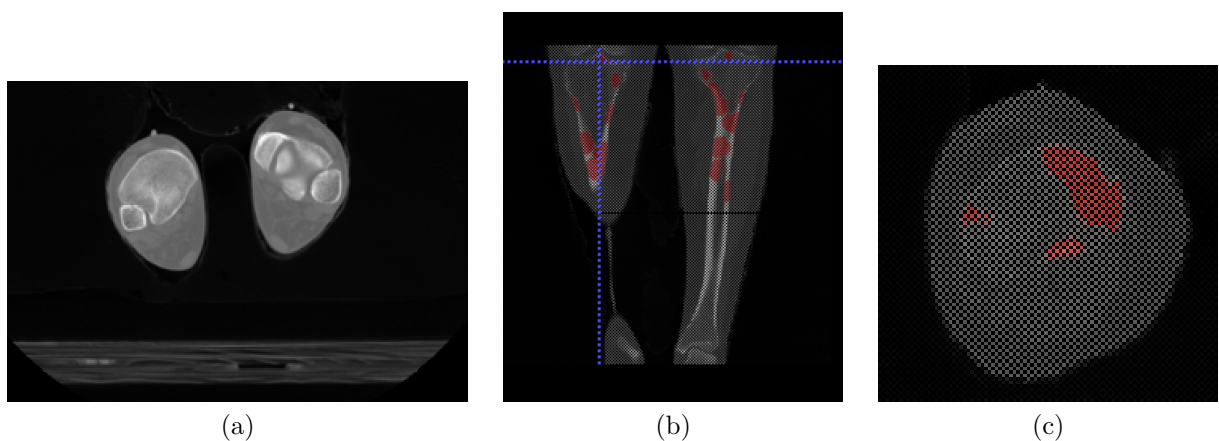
Segmentation process of the region R1 in ITK Snap [19], (a) original CT-scan image (b) the beginning of segmentation and (c) problematic region.
